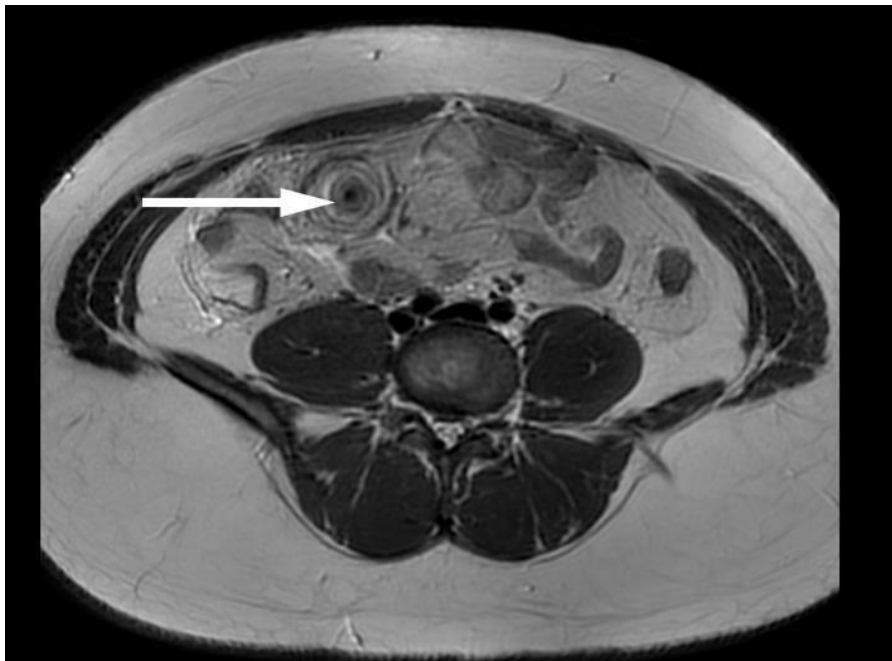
Magnetic resonance imaging (MRI) of the pelvis Axial T2 Weighted image: showed T2 hyperintense fat content
